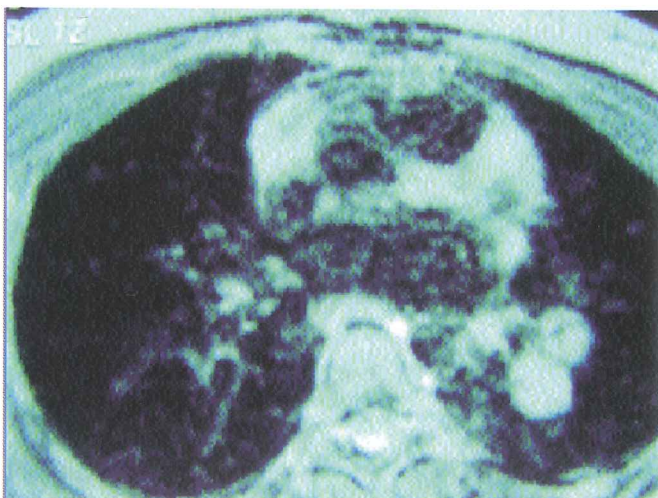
MRI image of the hydatid cyst in distal pulmonary artery.
